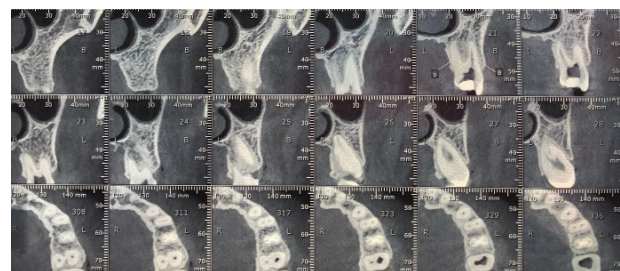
Cbct image of first maxillary molar with two roots and two canals
